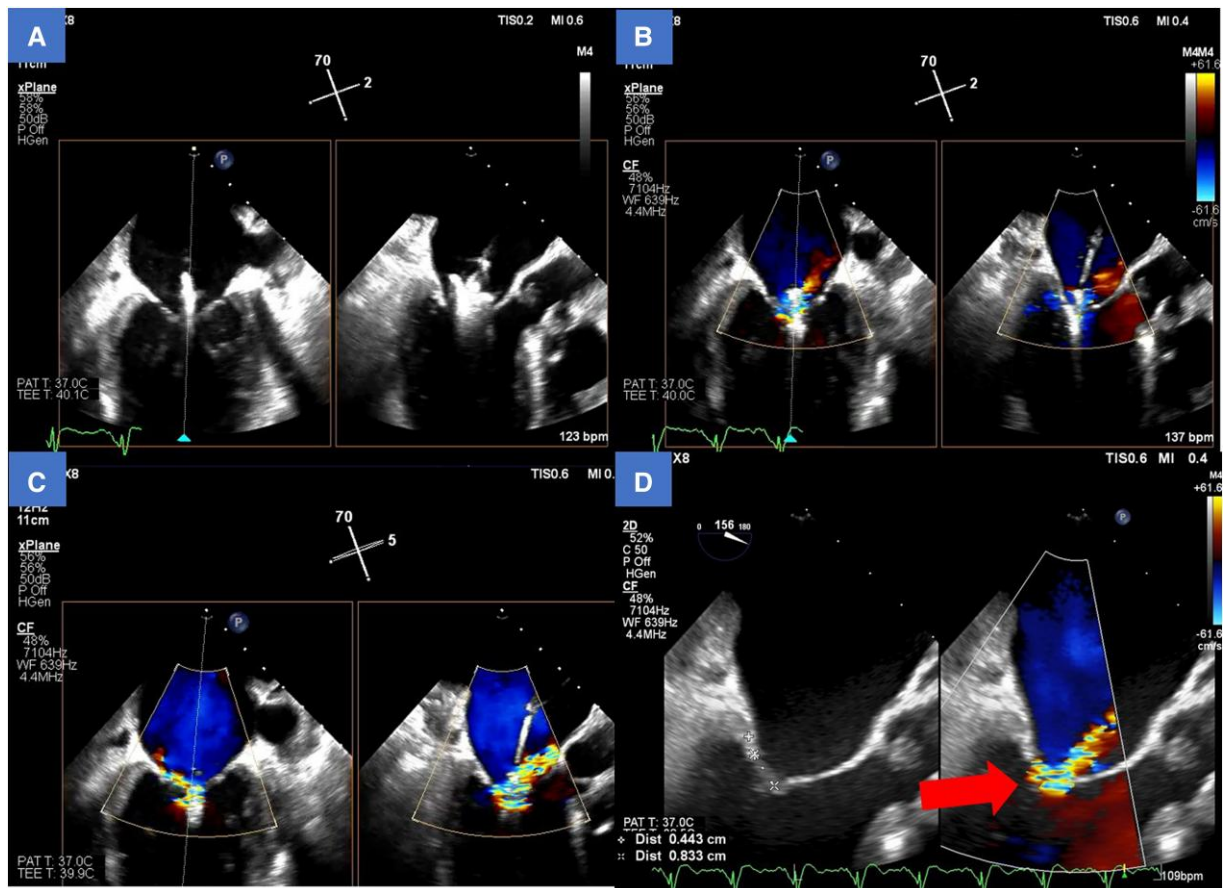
Intraoperative transoesophageal echocardiography until valve leaflet injury was recognized. (A) Positioning the NTV clip in line with central jet. (B) Mitral regurgitation decreased while the clip arm was closed. (C) Once the clip was completely closed, a new mitral regurgitation suddenly appeared. (D) The new eccentric jet came from the mid-portion of the posterior leaflet, indicating leaflet perforation caused by the clip arm. The distance from the tip of the posterior leaflet to the perforation site was around 8 mm.
